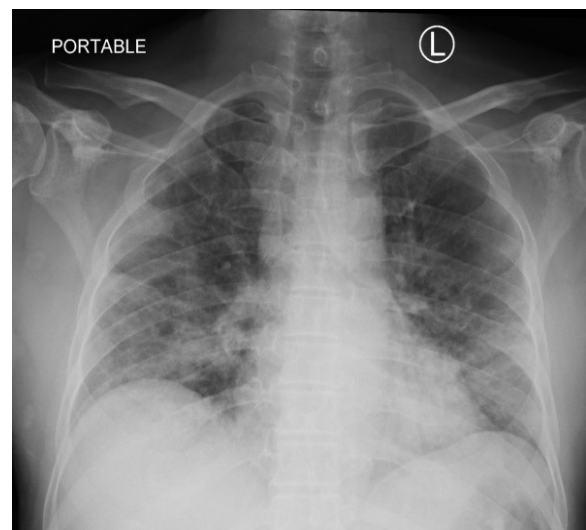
Chest radiograph showing bilateral multifocal peripheral subsegmental consolidations.
